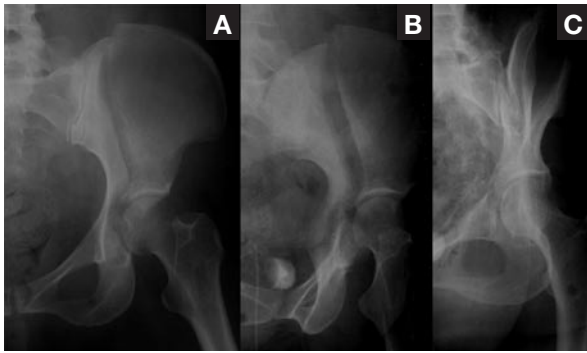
Anteroposterior (A), iliac oblique (B), and obturator oblique (C) plain radiographs of a displaced anterior column fracture (Orthopaedic Trauma Association 62-A). Such radiographs are obtained routinely in the emergency department.
